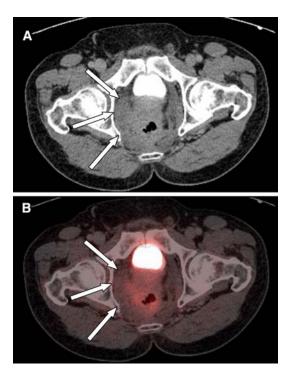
The axial CT (A) shows a pelvic mass in a patient three years after resection of a rectal carcinoma. PET/CT (B) found only minimal, inhomogeneous uptake of FDG of the lesion rated as scar tissue. No recurrent cancer was suspected. A subsequent biopsy confirmed this diagnosis.
